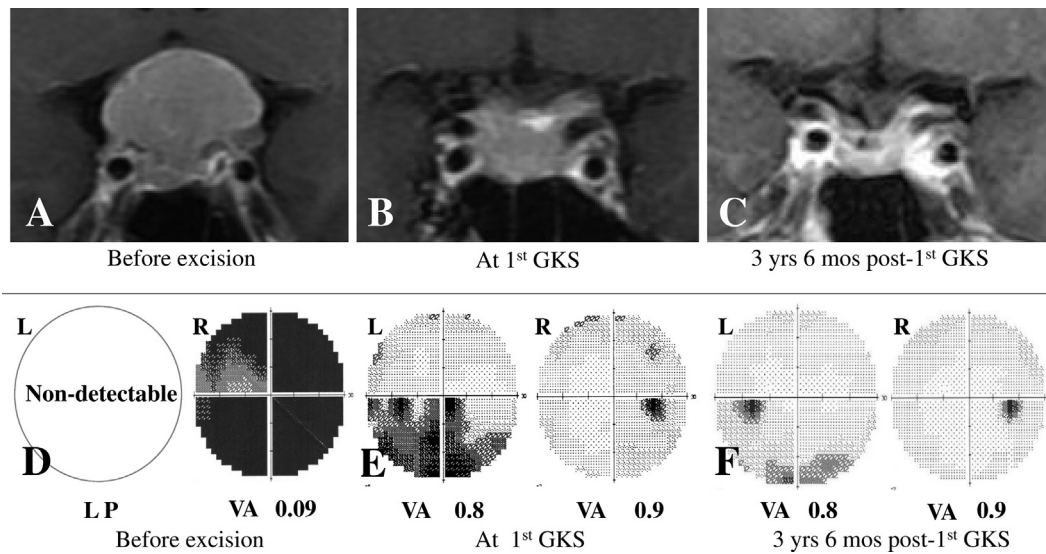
Case 4. (A) 43-year-old female patient presented with bilateral visual field deficits. The patient underwent surgical resection to decompress the optic chiasm. Post-resection, the patient's vision improved, with only lower visual field deficits of the left eye remaining. The patient underwent 3 fractions of GKS according to the snowman strategy. MRI revealed tumor shrinkage 3.5 years post-GKS, and visual function had improved even further (L = left, R = right, LP = light perception, VA = visual acuity).
